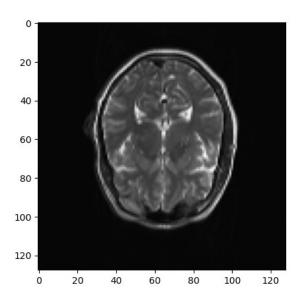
Output Slice Image of MRI Data from NII Files using Nibabel
